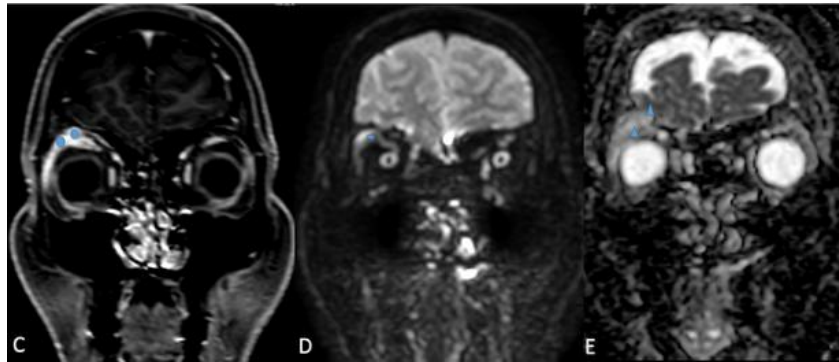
Gadolinium-enhanced T1 fat-saturated coronal (C, blue dot) shows contrast enhancement of the right lacrimal gland region. DWI coronal (D) demonstrates restricted diffusion of the lesion. T2 fat-saturated coronal (E, arrowheads) confirms T2 hyperintensity of the right superolateral extraconal mass.
